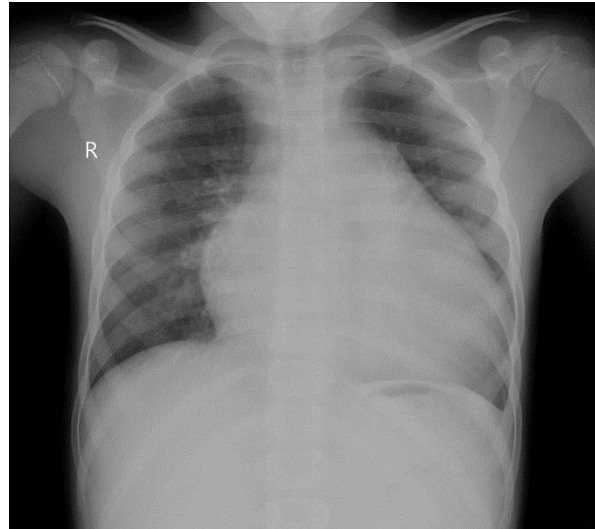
Sick D., 6 years old. On the chest x-ray in the direct projection, the heart is enlarged in both directions (more to the left), the heart arcs are not differentiated on both sides. Cardiothoracic index (CTI) =0.68. Stagnation in the lungs.
